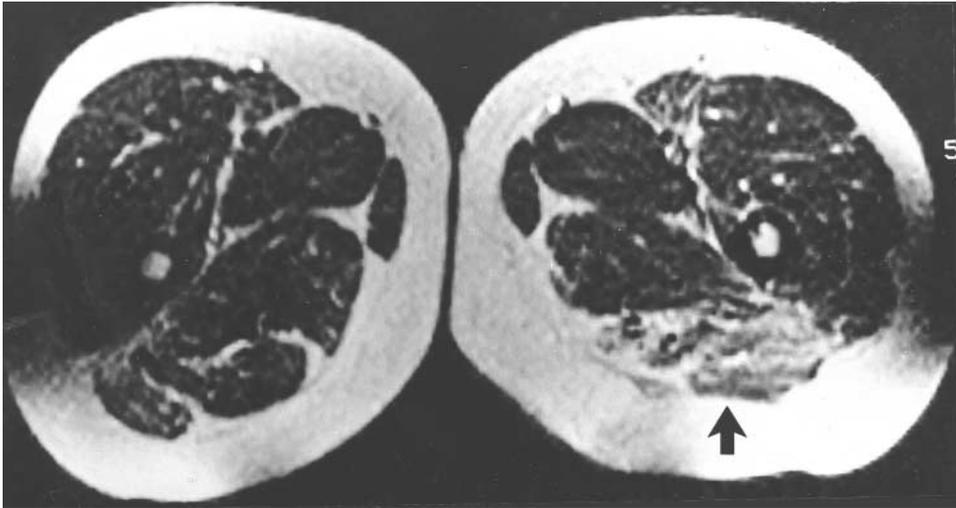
Follow-up axial T1-weighted MR image (TR, 500 ms; TE, 20 ms) shows atrophy and retraction of semimembranosus and semitendinosus muscles and fat infiltration (*arrow*) of the biceps femoris muscle
